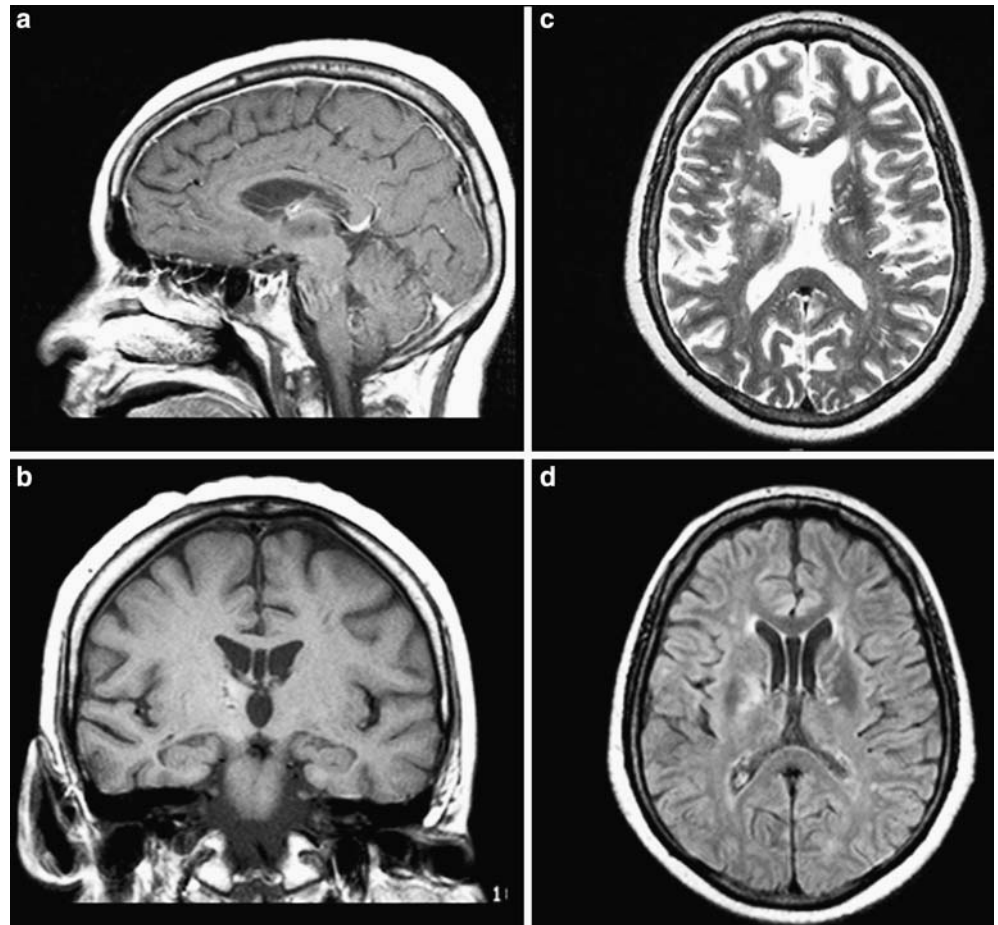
MRI in sagittal T1 (a), coronal T1 (b), axial T2 (c) and FLAIR (d) showing absence of tumor-like lesion and biopsy scar on right thalamus
